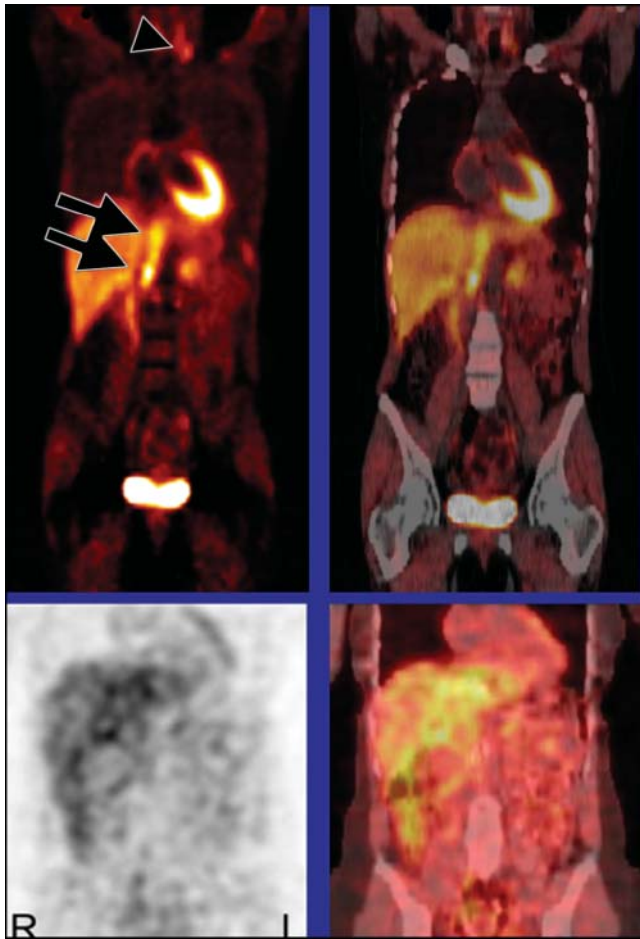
Tumors of the sympathetic nervous system were imaged with whole-body ^{11}C -HED PET/CT (top) and ^{123}I -MIBG SPECT/CT (bottom). PET was found to detect more lesions.
